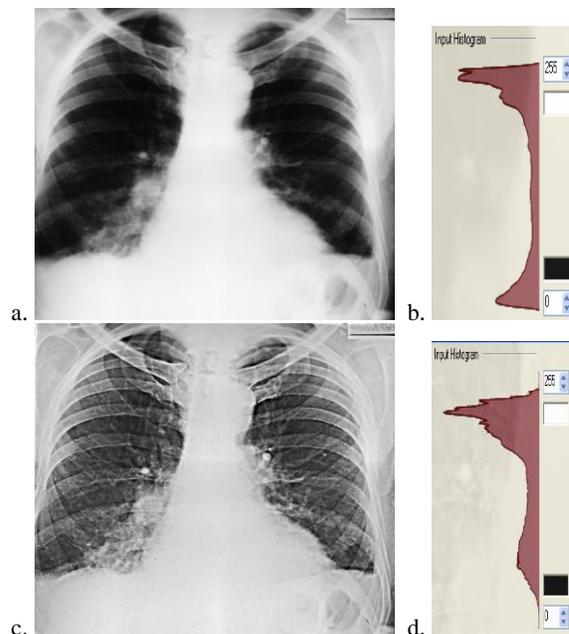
The overexposed X-ray image: a) a digitalized generic image and b) its histogram; c) the image after correction (without medical artifacts) and d) its histogram.
